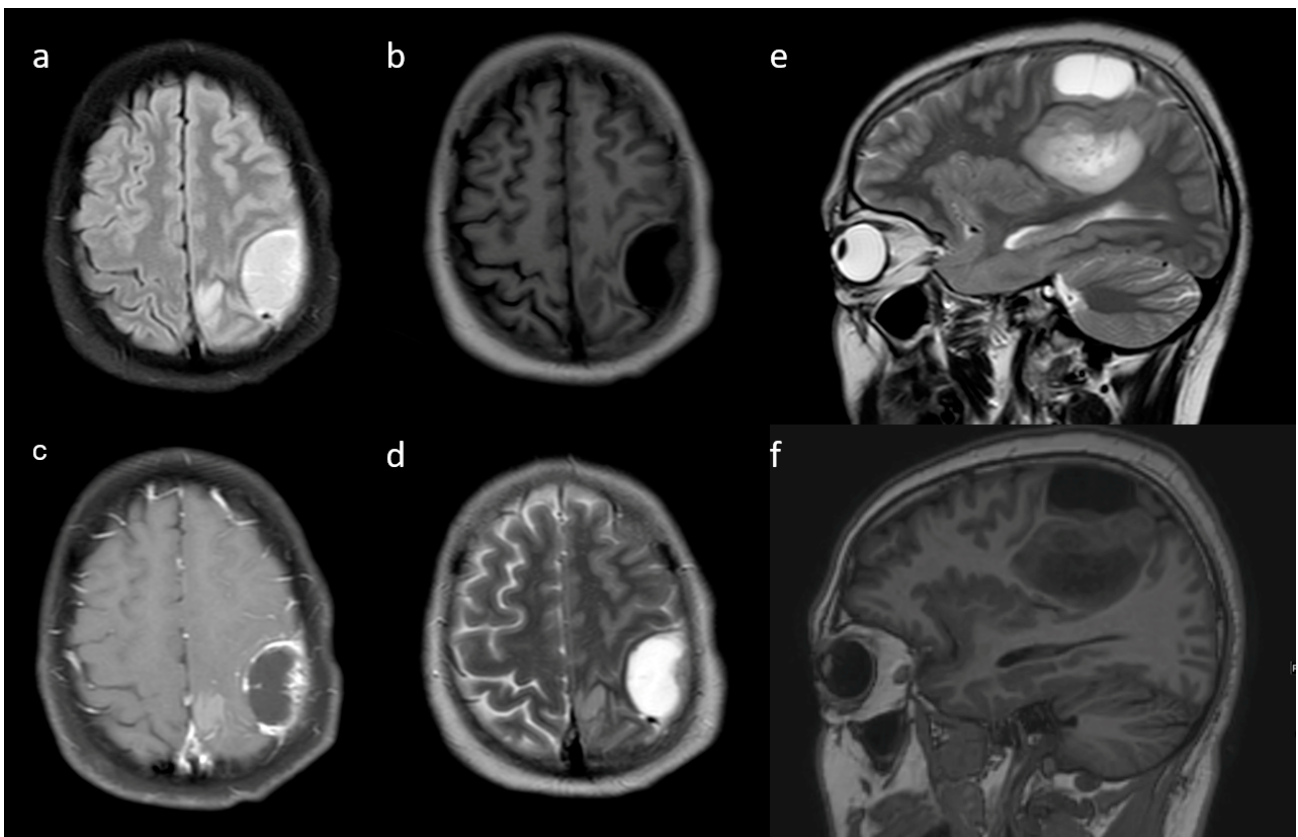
(a–d) Axial T1w, T2w, FLAIR, and post-contrast T1w images reveal a peritumoral cyst adjacent to the primary tumor. Additional (e,f) sagittal T2w and sagittal T1w are also shown.
